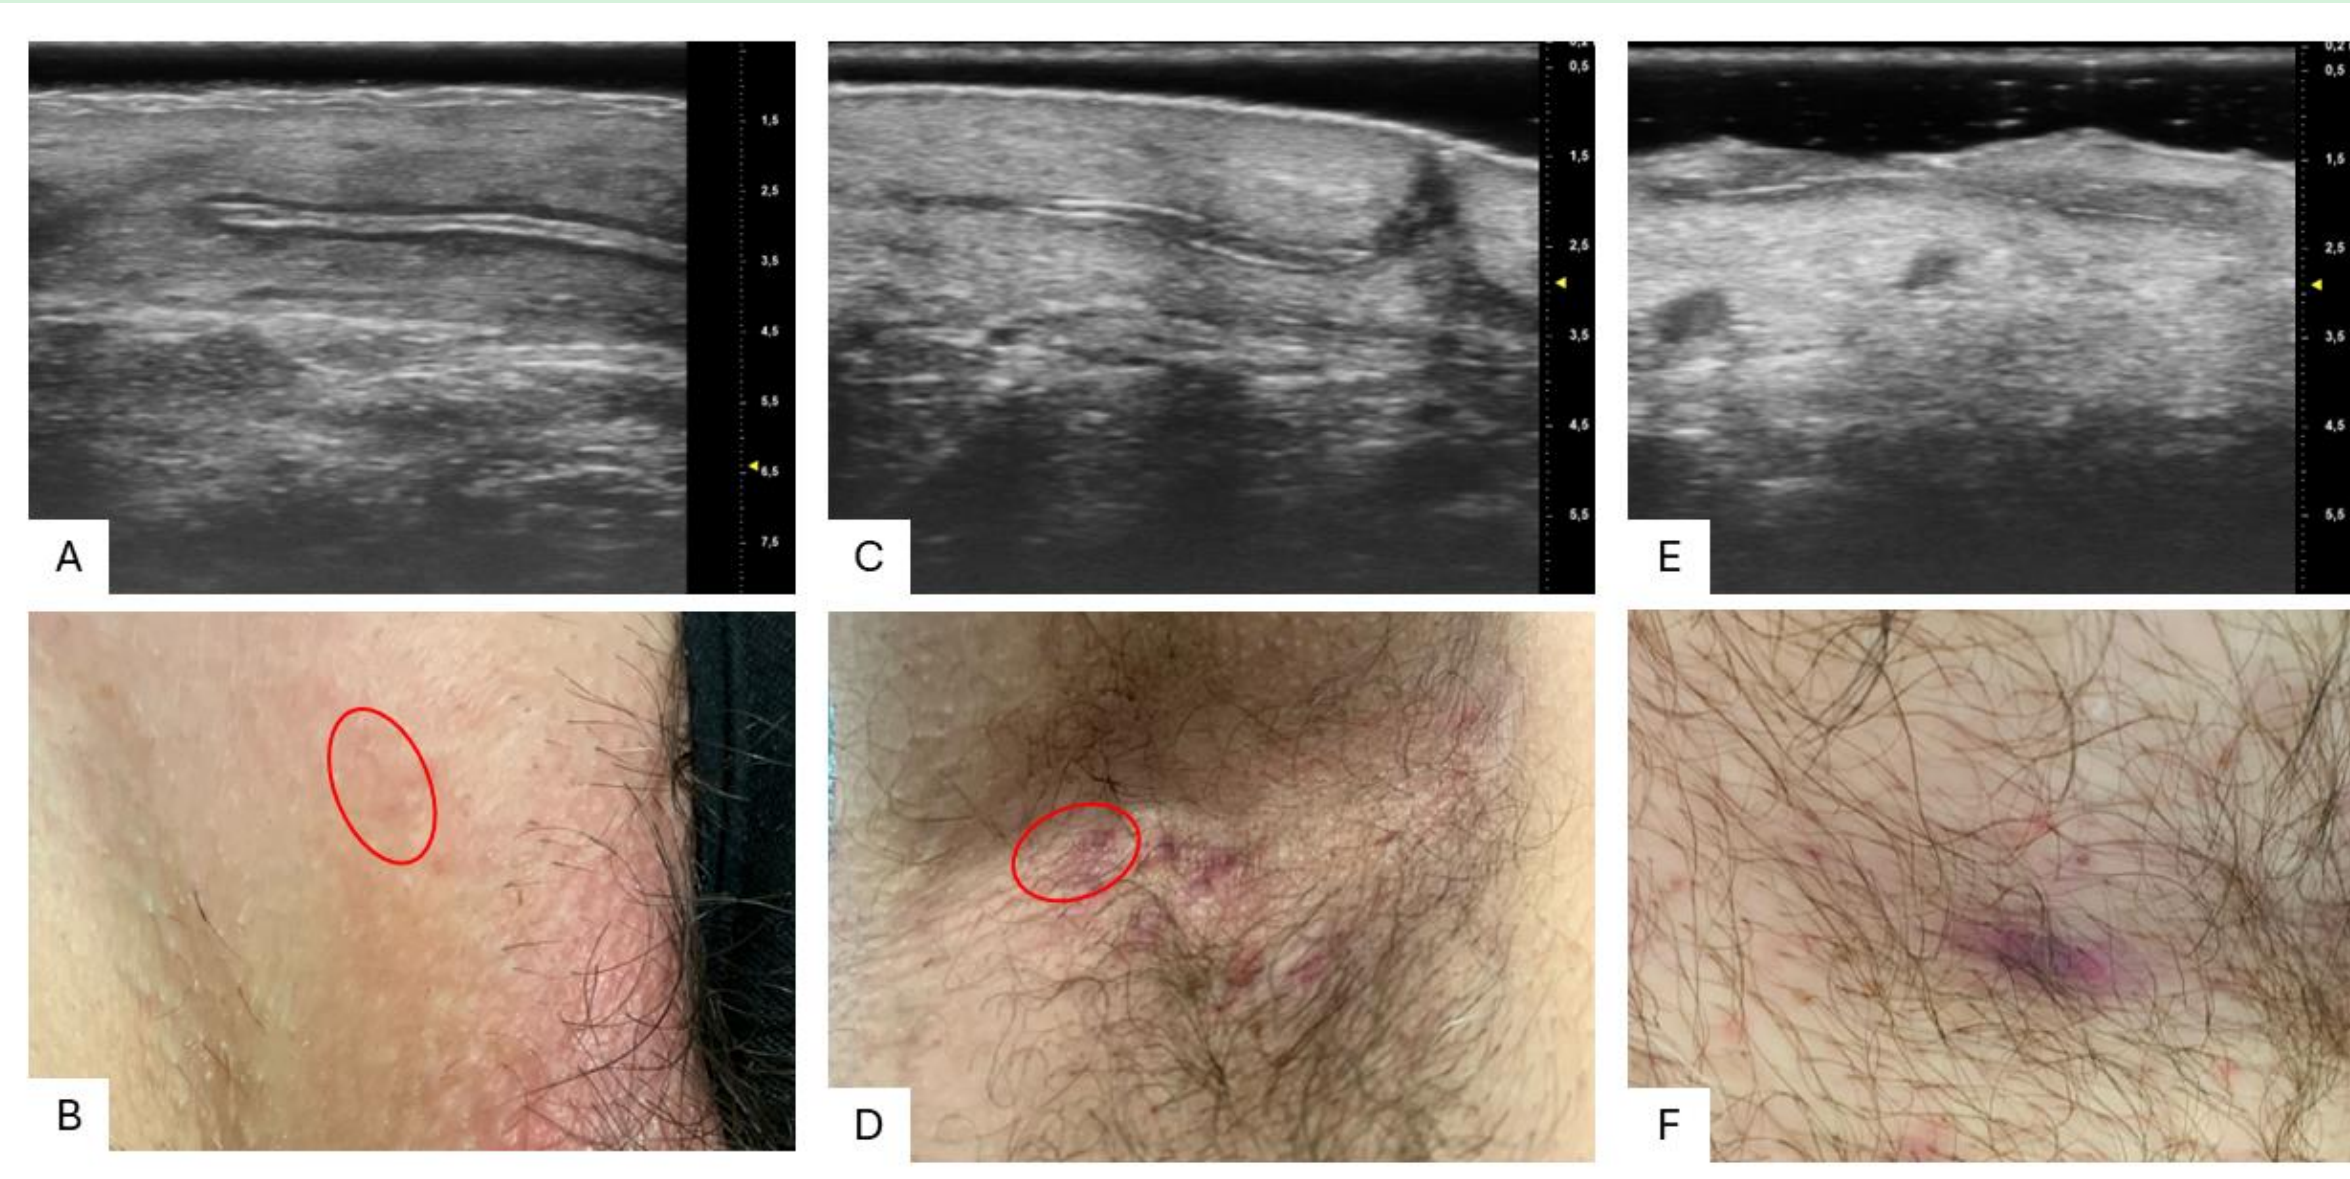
Ultra-High Frequency Ultrasound (UHFUS) Guided Approach for determining precise location of HS tunnels.
